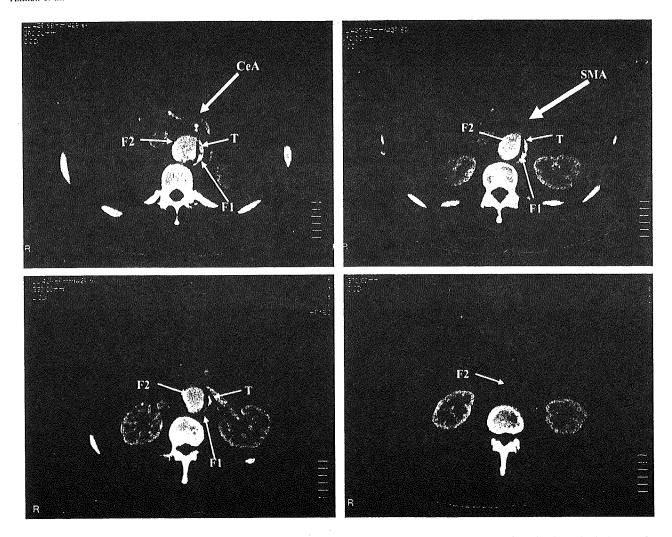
A computed tomography (CT) scan obtained upon arrival (2 years after the first occurrence of aortic dissection) shows a 3-channel dissection. A newly formed false lumen (second false lumen: F2) is seen anterior to the true lumen (T). The first false lumen (F1), which developed at the time of the first occurrence of aortic dissection, is difficult to identify because of the compression by the second false lumen. The true lumen, from which the celiac and the superior mesenteric arteries arise, is also compressed by the second false lumen.
